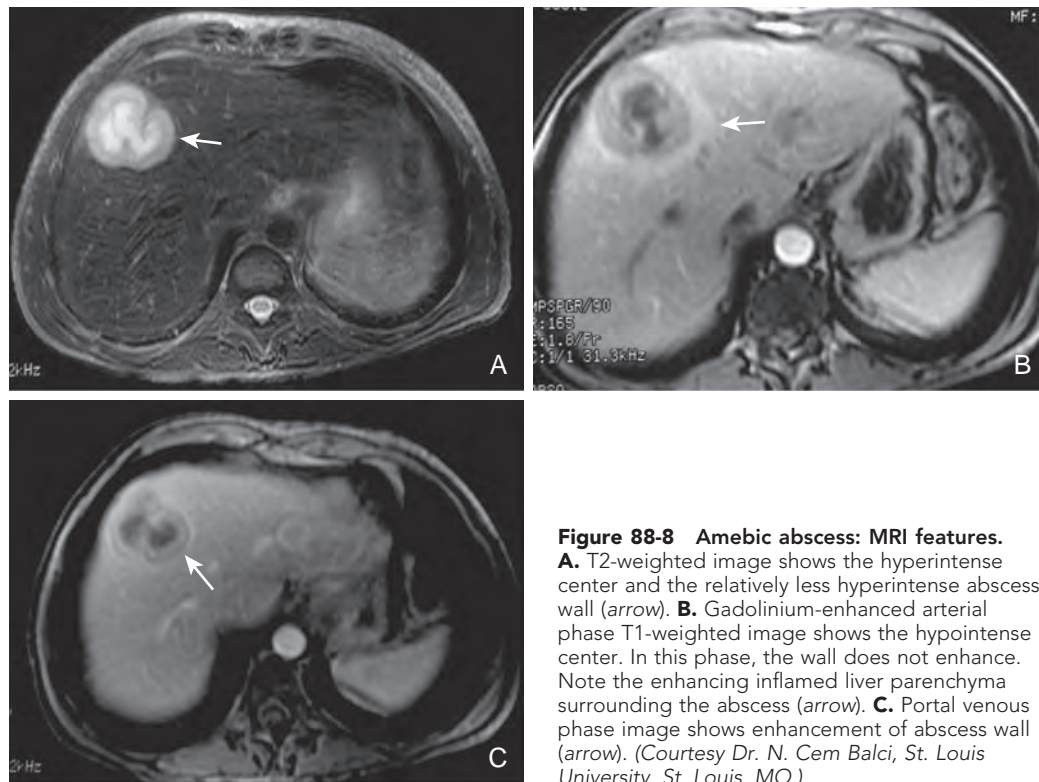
Amebic abscess: MRI features.
